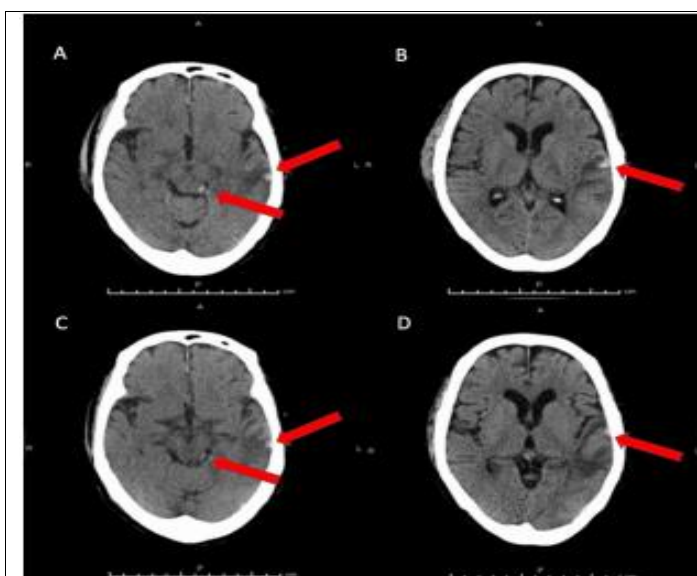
Axial CT on hospital day 2 (A and B) and 7 (C and D). There is no evidence of hemorrhage enlargement. The lesions are identified by red arrows.
